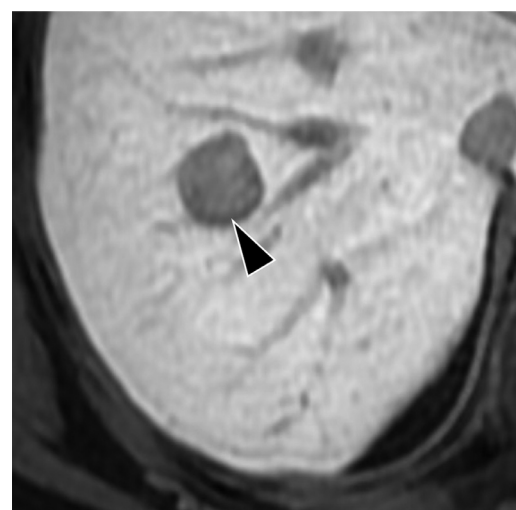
MR imaging exam performed with gadoxetic acid in a 45-year-old man. The hepatobiliary phase in this hemangioma demonstrates a perilesional rim of hypointensity (arrowhead) relative to its center known as peripheral low intensity rim.
